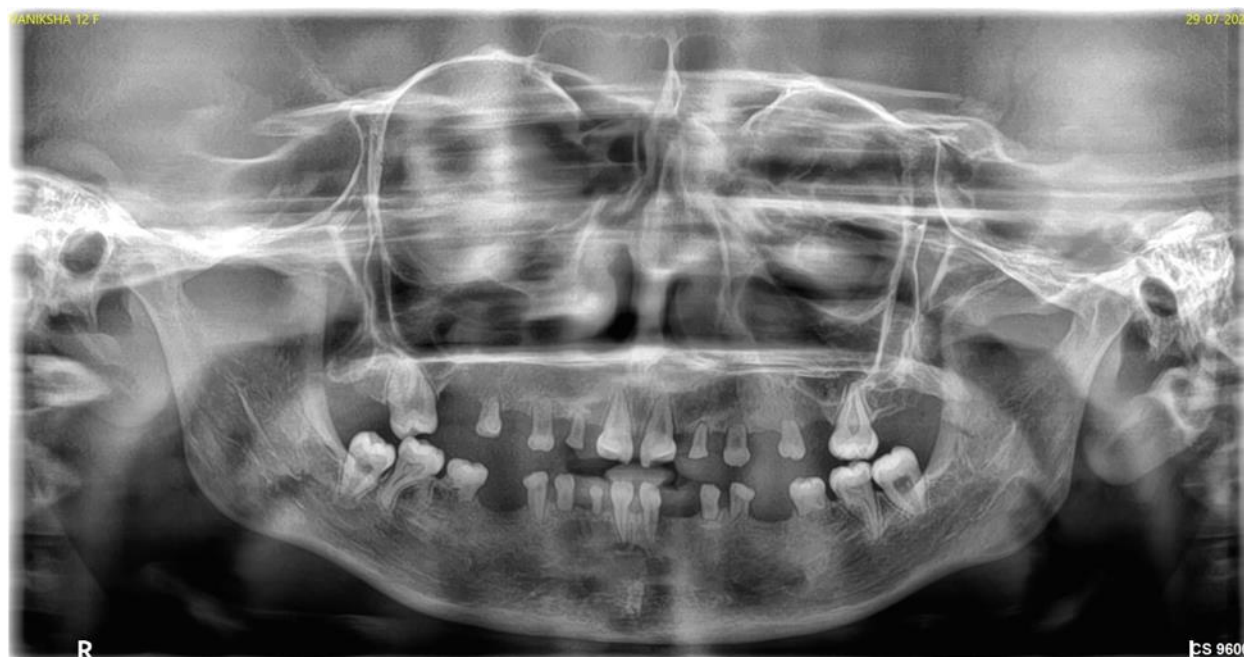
Panoramic radiograph (pantograph report) demonstrating congenitally absent teeth with remaining permanent dentition whose roots are showing open apices.
